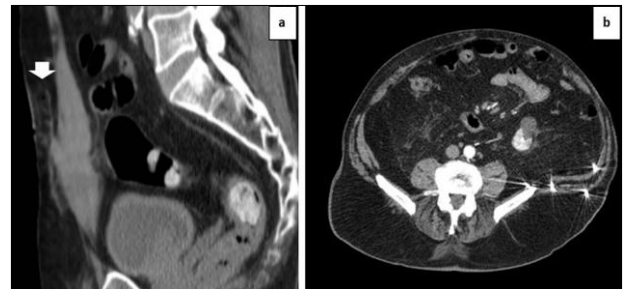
Stab injury lower abdominal wall. a) Pelvic CT Sagittal with indurated track and wall haematoma. b) Axial CT of multiple bullet injury with pellets impacted in left flank.
